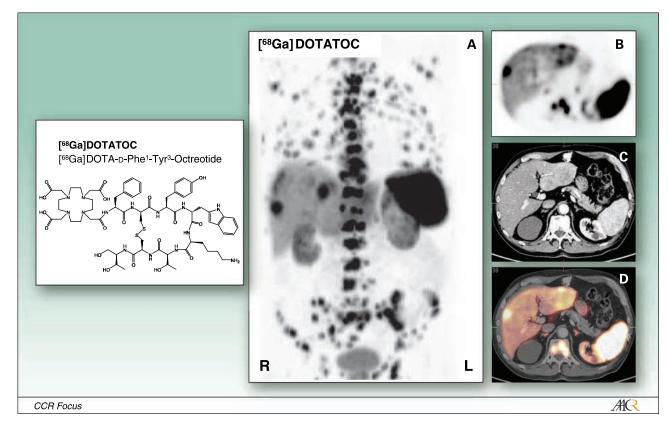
[⁶⁸Ga] DOTATOC-PET/CT. [⁶⁸Ga] DOTATOC-PET/CT of a patient with neuroendocrine cancer and hepatic/osseous metastases. Multiple lesions with intense tracer uptake in somatostatin receptor 2 – positive metastases of the liver, vertebral column, pelvis, scapula, and femur. *A,* maximum intensity projection of [⁶⁸Ga] DOTATOC-PET. *B,* transaxial section of [⁶⁸Ga] DOTATOC-PET. *C,* corresponding transaxial section of CT. *D,* fused image ([⁶⁸Ga] DOTATOC-PET/CT).
